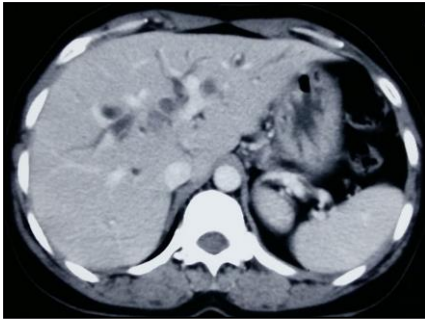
Contrast-enhanced CT scan showing bilateral hepatolithiasis.
